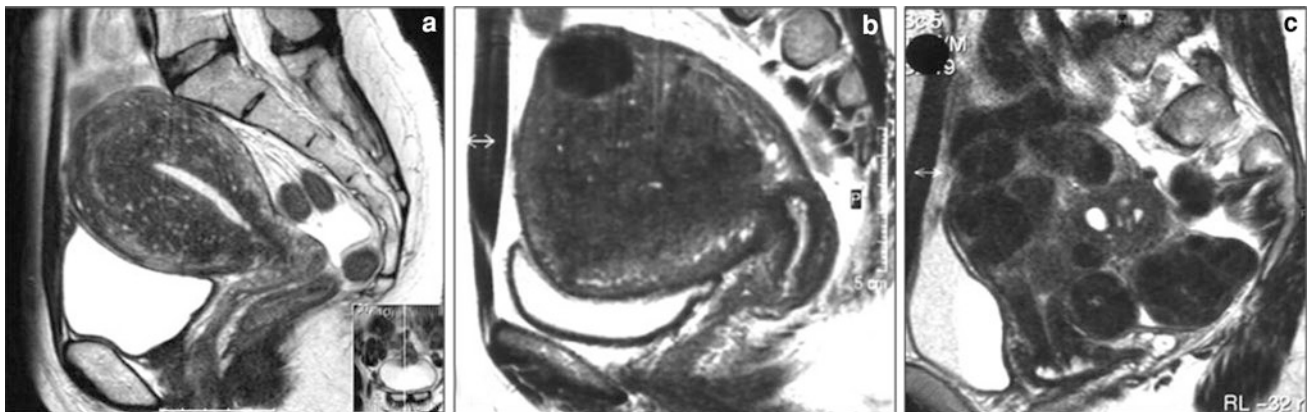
Sagittal T2-weighted MRI of different types of adenomyosis. a Diffuse pure adenomyosis; b adenomyosis dominance with fibroid; c adenomyosis with fibroid dominance
